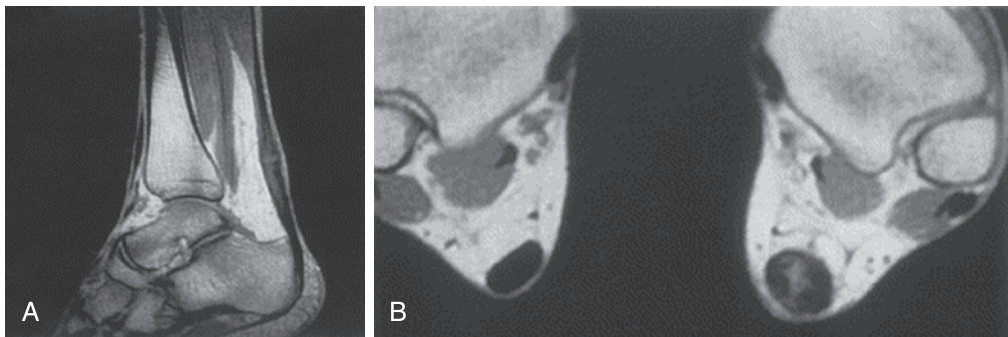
Magnetic resonance imaging of chronic, degenerative tendinosis with thickening of the tendon in the sagittal (A) and coronal (B) planes compared with the opposite Achilles tendon. (From Lesic A, Bumbasirevic M. Disorders of the Achilles tendon. *Curr Orthop*. 2004;18(1):63–75.)
